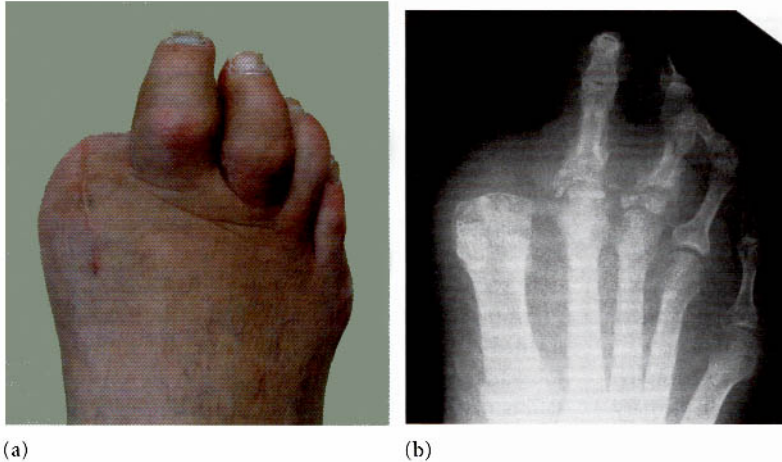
Hallux amputation in a neuropathic patient. (a) Clinical appearance 5 months following disarticulation of the hallux at the metatarsophalangeal joint, with medial and lateral skin flaps for closure. There is moderate to severe swelling of the 2nd and 3rd toes. (b) Anteroposterior radiograph reveals pathological fractures of the proximal phalanges of the 2nd and 3rd toes.
